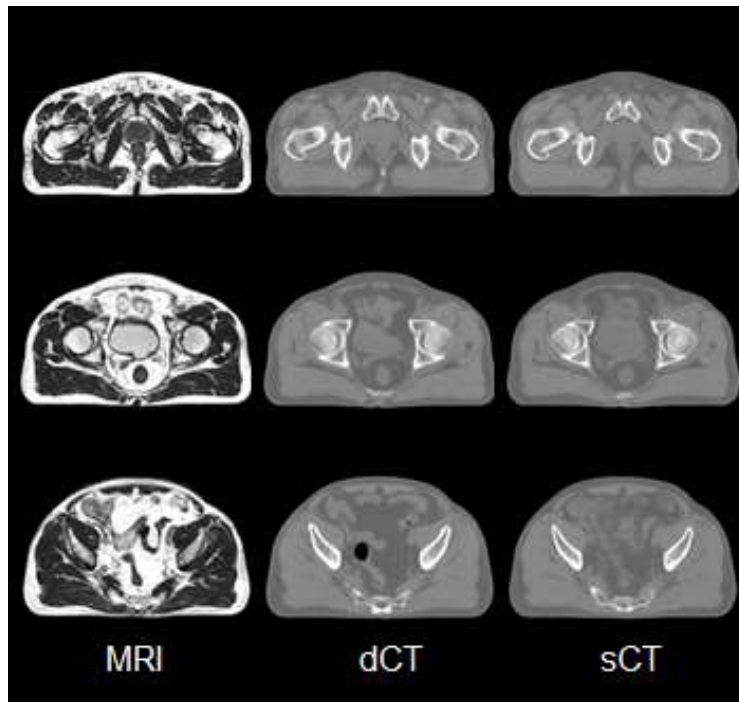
The representative axial slice views of MRI, dCT and sCT for pelvis
